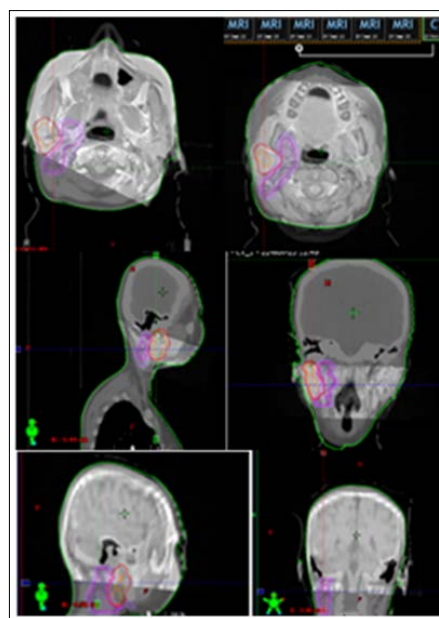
Preparation for Delineating the Target Volumes After Fusion of The MRI Image and That of The Planning CT
